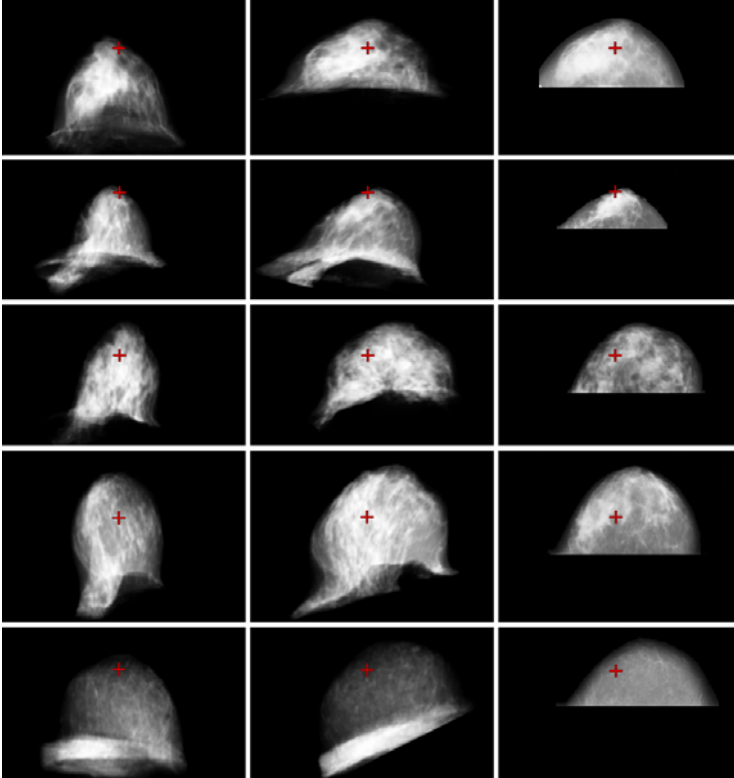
Registration results on real data (5 cases/rows). From left to right: projection of the source volume before registration, after registration and real X-ray mammogram. The red cross indicates the position of a corresponding coordinate in each image.
